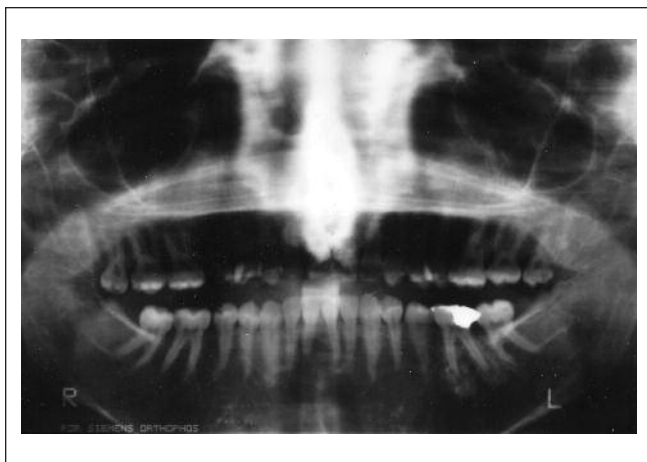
Panoramic radiograph of an 18-year-old thalassemic girl revealing spiky short roots, faint lamina dura and borders of the mandibular canal, and enlarged marrow spaces.
